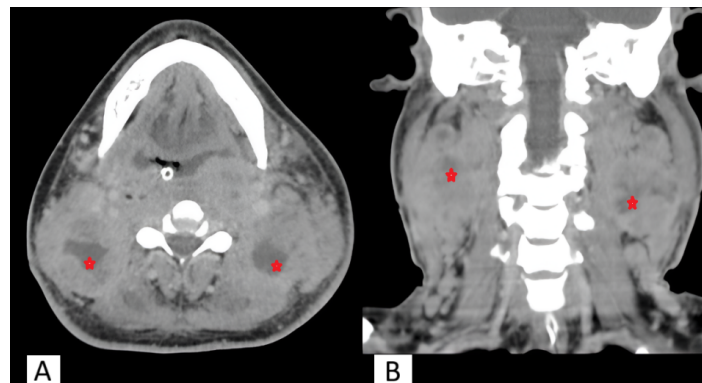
CT neck (A, axial view; B, coronal view) showed multiple enlarged cervical nodes with necrotic components (asterisk) within over bilateral neck level II, III, and IV
